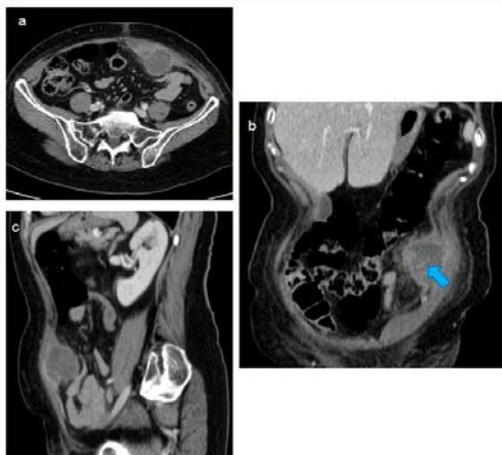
Abdominal enhanced CT revealing 5.5 cm x 4.5 x 3.5 cm hypodense collection in the left rectus muscle with fish bone (blue arrow) inside. a. axial view. b. coronal view. c. sagittal view.
